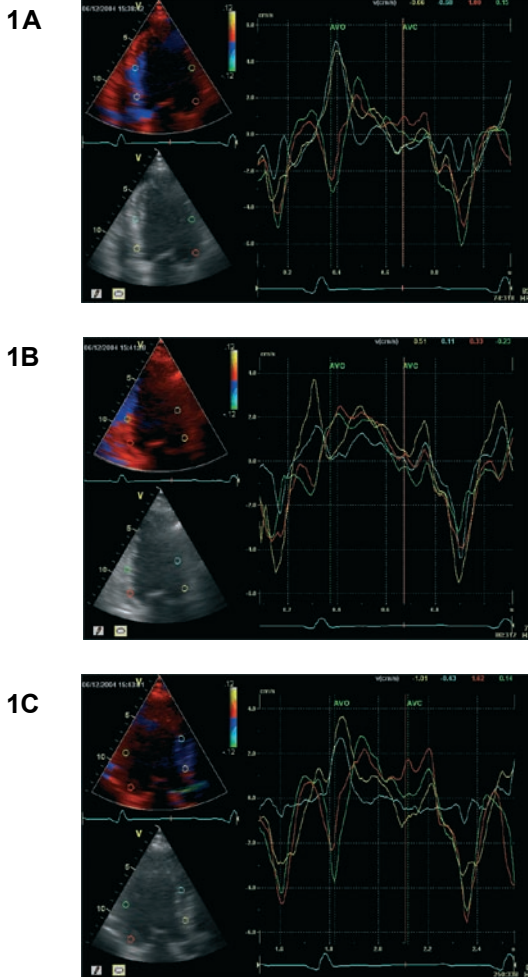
12-segment color-coded tissue Doppler imaging in patient with LV dyssynchrony in multiple segments. Myocardial velocity curves were derived off-line at basal and mid levels of the left ventricle in the different walls. The time to peak systolic velocities during the ejection phase in each view are compared. The ejection phase is defined by the aortic valve opening (AVO) and aortic valve closure (AVC) markers. Panel A: Apical 4-chamber view showing delay in the lateral wall. Panel B: Apical 2-chamber view showing delay in the anterior wall. Panel C: Apical long-axis view showing delay in the posterior wall.
